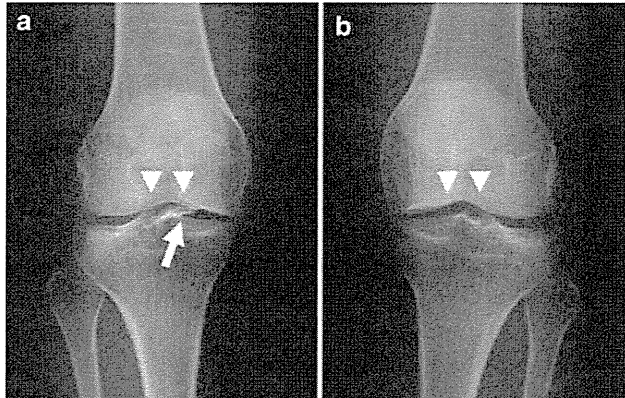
Anteroposterior radiographs of both knees showed a shallow femoral trochlear groove (*arrowheads*) and flattening of the medial femoral condyle. a Radiograph of the right knee showing a loose body (*arrow*). b Radiograph of the left knee
